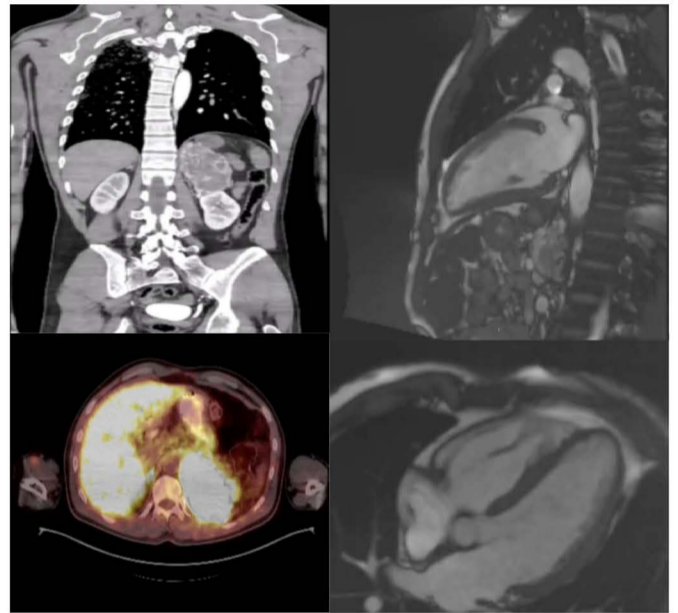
Incidentally, a left adrenal mass compressing the kidney was detected on CT. Cardiac MRI revealed an apical aneurysm, while PET-CT demonstrated a 10 × 6.5 cm adrenal lesion with central necrosis and intense DOTATATE uptake (SUVmax: 75.5), consistent with pheochromocytoma.
